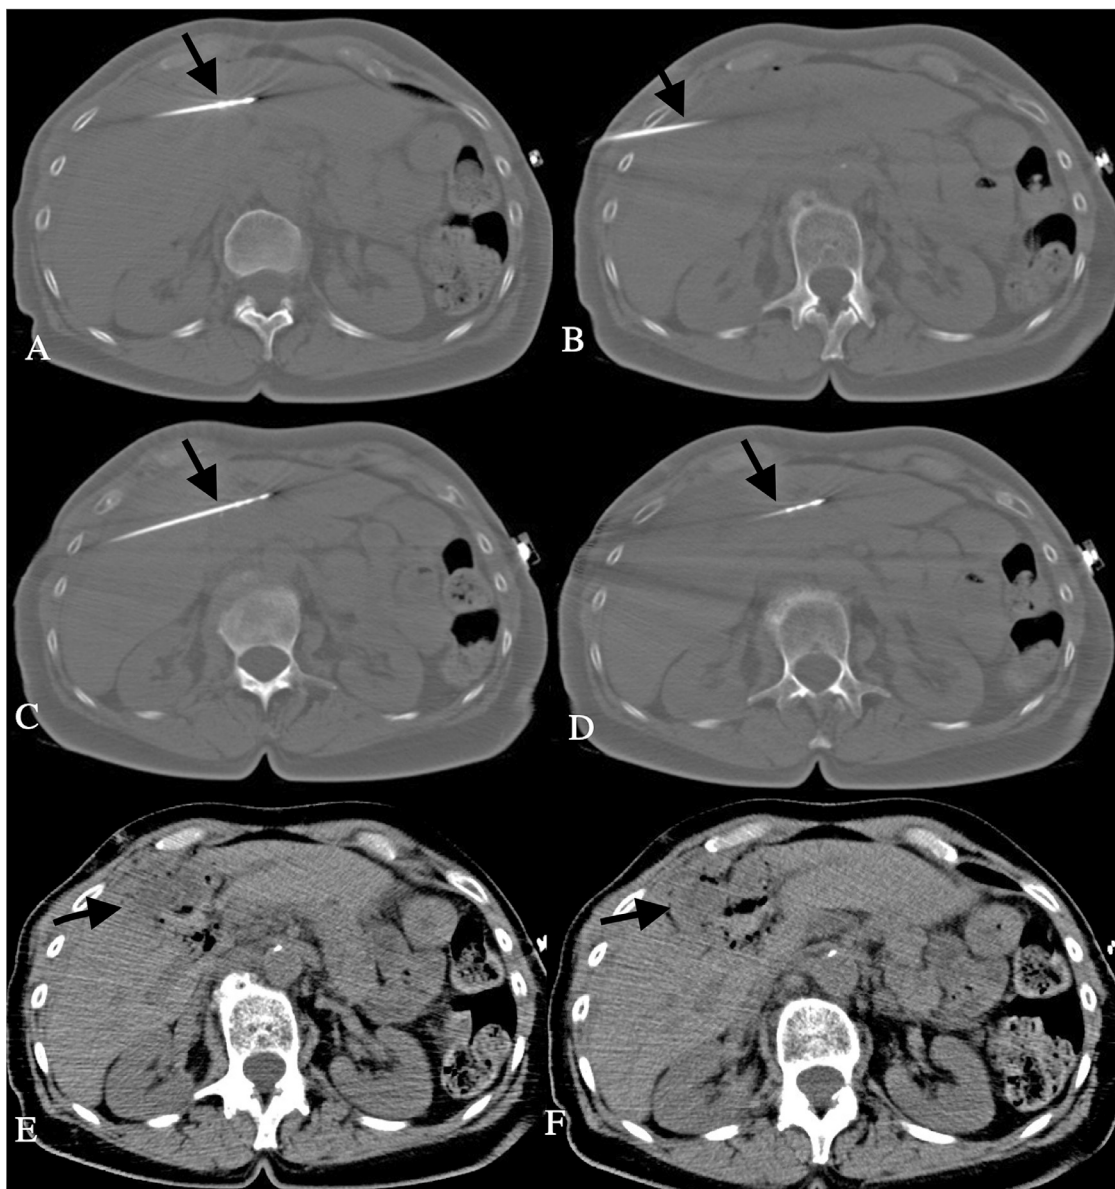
Placement and results of MWA. (A and B) First needle placement for MWA, using 17gauge, 15 cm PR-15 (NeuWave, Johnson and Johnson, New Brunswick, NJ). (C and D) Second needle placement for MWA using 17-gauge, 15 cm PR-15 (NeuWave, Johnson and Johnson, New Brunswick, NJ). (E and F) Axial CT scans show the large ablation zones immediately after MWA.
